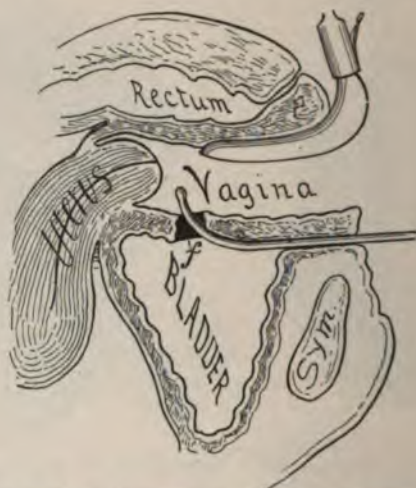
DIAGNOSIS OF A VESICOVAGINAL FISTULA BY INSPECTION (page 773).
